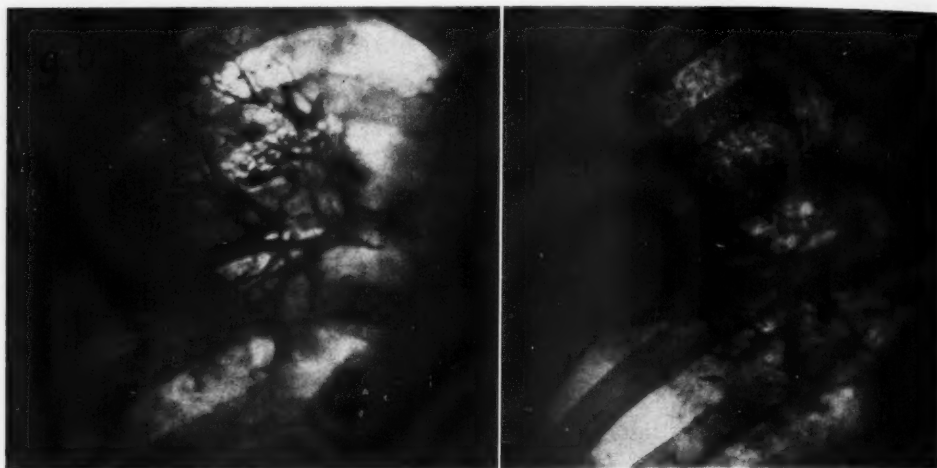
Control of the motion of the lipiodol filling of the bronchi while the breath is held. The lipiodol is first seen in the foremost parts of the bronchi, before it begins, with the pulsation, to undergo a rhythmical translocation into the bronchioles, as is shown by the next roentgenogram.
